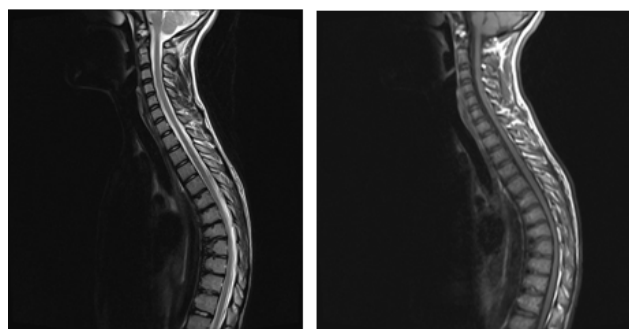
MRI thoracic spine showing features of Scheuermann's disease.
